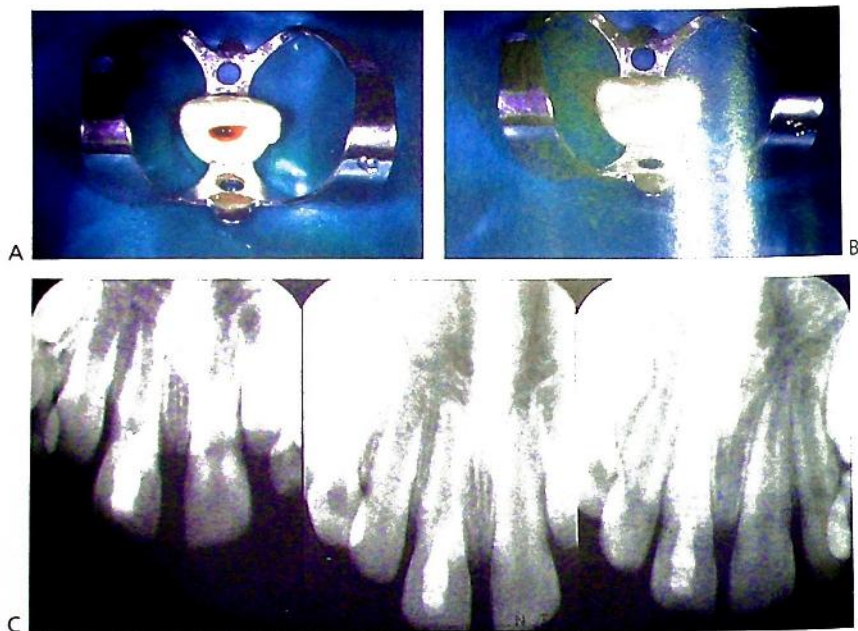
Pulp revascularization. (A) Haemorrhage is induced into the canal by passing a file through the apex of this immature tooth. (B) Mineral trioxide aggregate (MTA) is placed over the clot at the level of the cemento-enamel junction (CEJ). (C) Periapical radiographs of an open-apex tooth treated with this new technique. Over 3 and 12 months, there has been further development and closure of the root apex.
